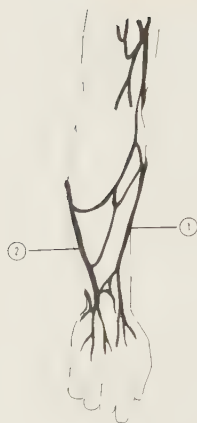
MAIN VEINS OF THE FOREARM DORSAL ASPECT.
